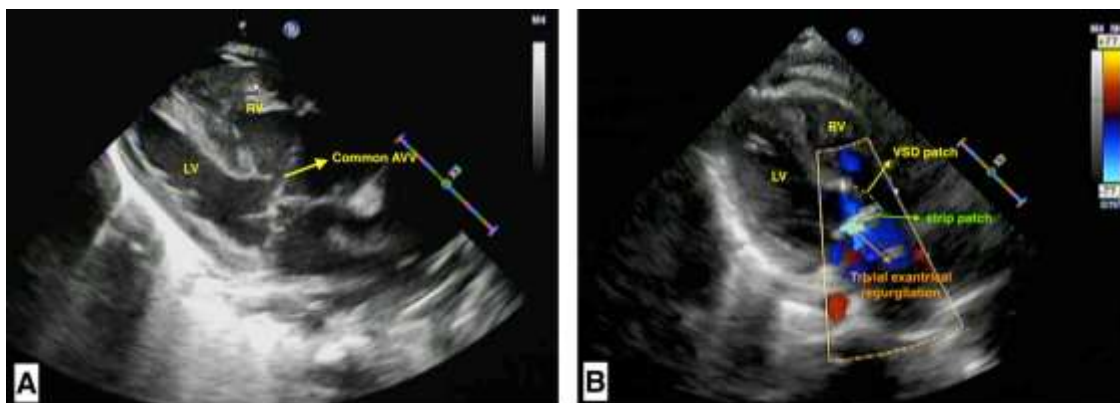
Preoperative (A) and postoperative third month (B) transthoracic echocardiographic images. Note that there is trivial exanttrial regurgitation in left-sided AV valve.
